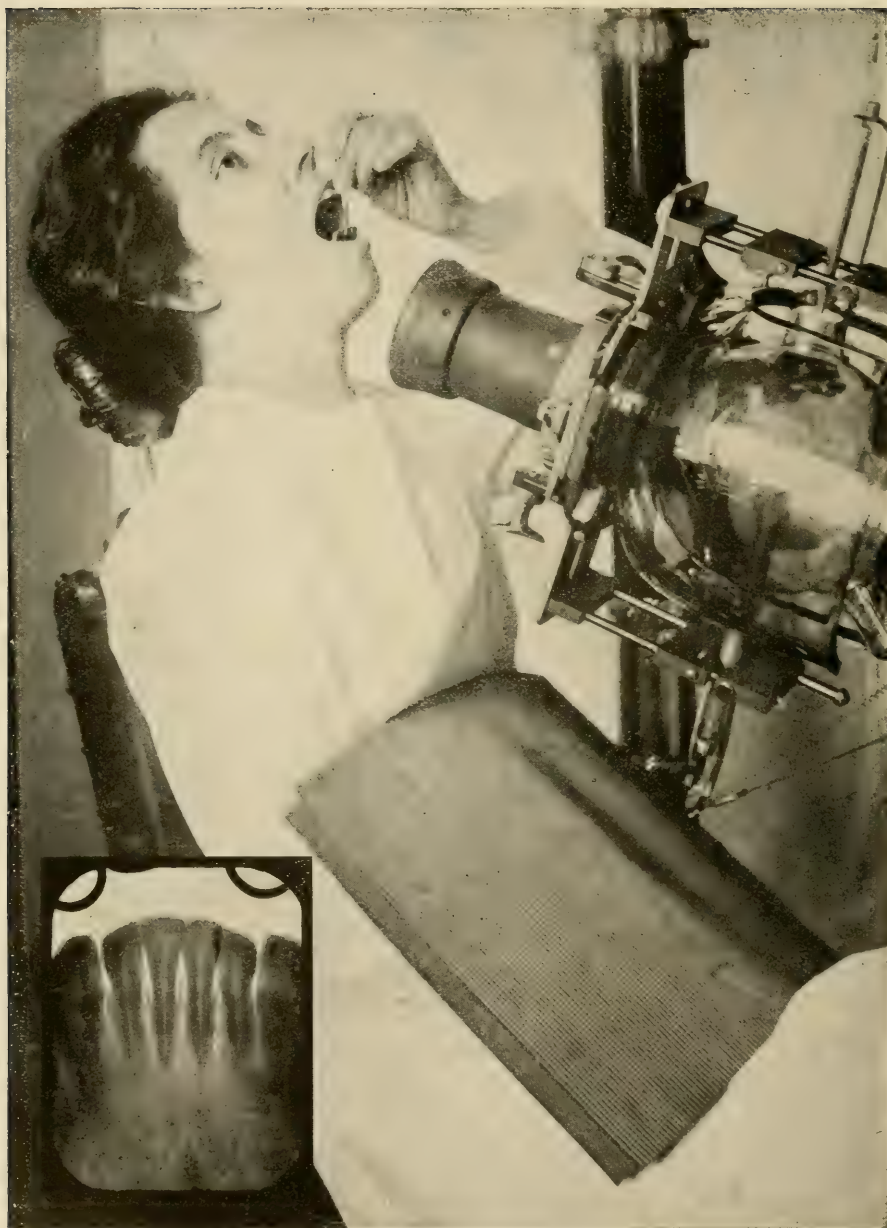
Pose for radiographing the lower anterior teeth with the position of the film as in Fig. 101. Radiograph made from this pose. (Note the rubber matting covering the patient where one of the terminals of the tube is brought close to the body. The rubber matting acts as an insulation preventing sparking of the current into the patient.)
